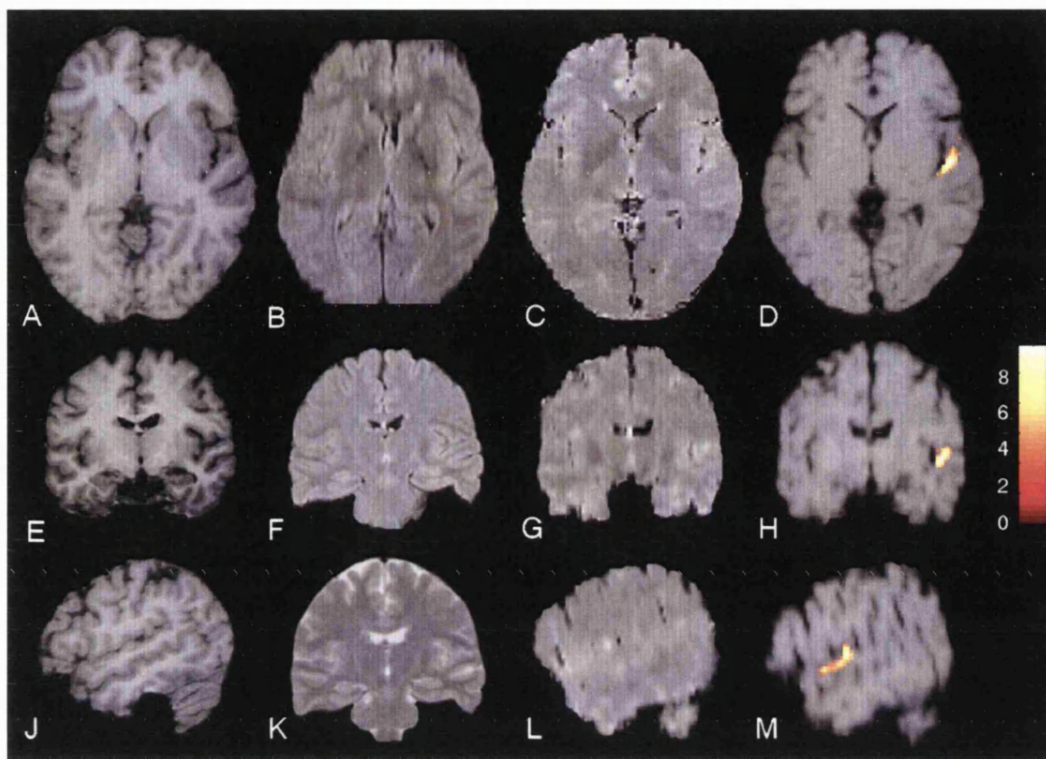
Patient 35. Patient with right temporal lobe epilepsy and normal conventional MRI. (A, E, J) Axial, coronal, and sagittal T1-weighted images. (B, F) Axial and coronal FLAIR images. (K) T2-weighted coronal image. (C, G, L) Axial, coronal, and sagittal T2 maps. (D, H, M) Regions of significantly increased T2 superimposed on axial, coronal, and sagittal early-echo (proton-density weighted) images. These regions were used for quantitative region-of-interest analyses on the T2 maps (Table 5.4). The region over the right superior temporal gyrus (Heschl's gyrus) localised to normal appearing cerebral tissue and concurred with electroclinical data regarding site of seizure onset. Z-value bar indicating degree of significance of highlighted regions is shown. Note that right on the images is patient's right.
